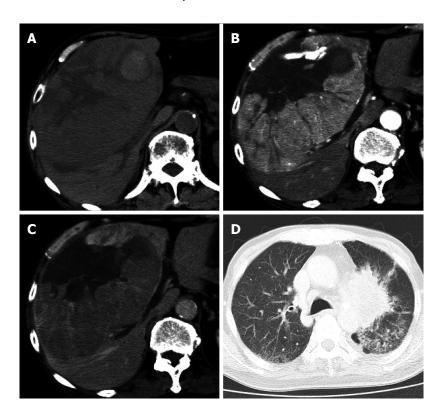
Contrast enhanced computed tomography image of the abdomen shows a huge tumor that occupies the right hepatic lobe, with enhancement in a viable lesion. A: Non-contrast phase; B: Hepatic arterial phase; C: Portal vein phase; D: Computed tomography image of the chest shows a primary lung cancer in the hilar side of the left lung.
